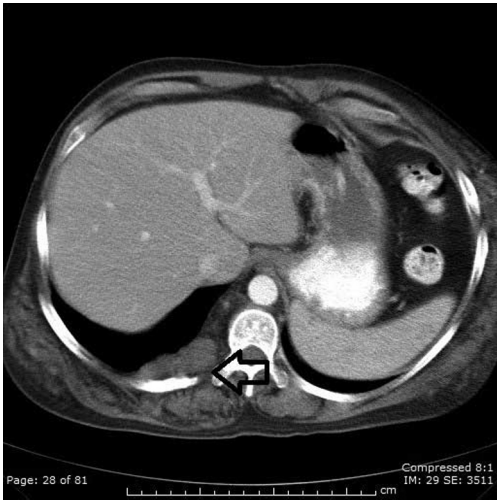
Proteus Syndrome in a 26-year-old male. Axial CT. An 8 x 2cm soft-tissue mass appears posterior to the right crus (black open arrow). Also note diffuse soft-tissue infiltration of the right flank musculature, thought to be secondary to subcutaneous nevi.
